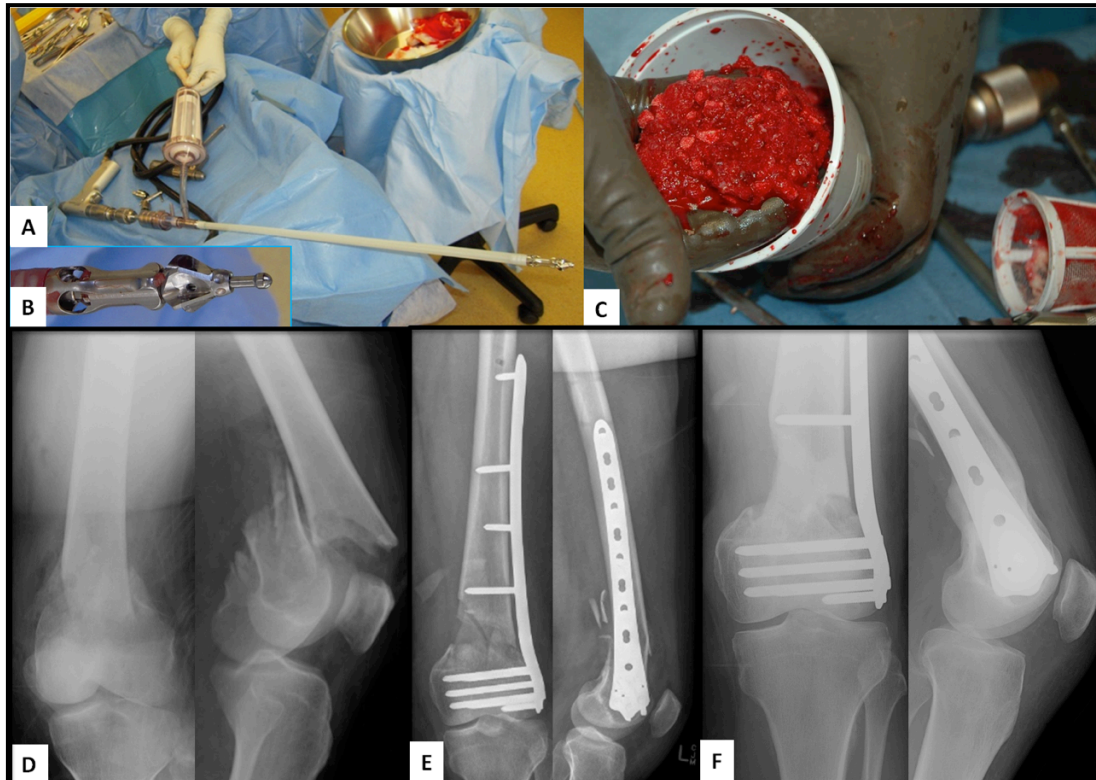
Collection of autologous osseous particles mixed with bone marrow (B), by using the reamer-irrigator-aspirator (RIA) system (A). The drill head of the system applies irrigation and aspiration to the medullary canal. An open distal femur fracture of an 32-year old male patient after an motor bike accident was stabilized using a LISS-plate (D). The radiographic images after surgery showed a remaining bone defect, which were treated in a second operation with autologous bone particles and bone marrow obtained via intramedullary reaming by using the RIA system (E). The follow up radiographic images after 6 months showed bony union (F).
